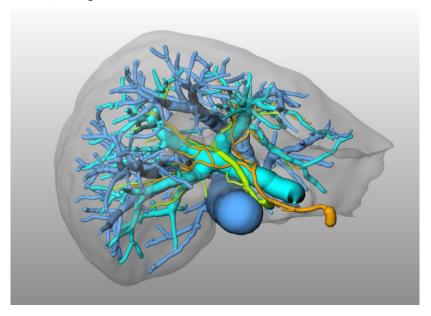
Vascular structures extracted from CT data. Hepatic artery (orange) and bile ducts (green) twine around the portal vein (cyan). The hepatic veins (blue) reach between the branches of the portal vein as the fingers from one hand between the fingers of the other hand. This patient has an inferior vein (small blue branch at the lower image border) and a variant of the portal vein, a trifurcation (image center).
